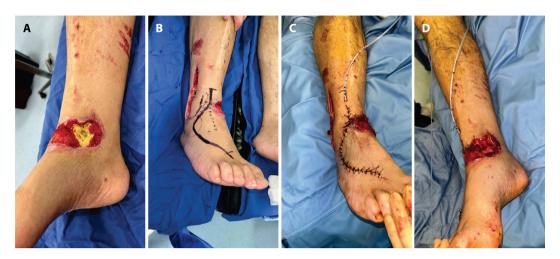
Intraoperative view. A. Bone exposure of the medial malleolus after two surgical debridements and NPWT. B. Preoperative markings. The dotted line represents the lateral tarsal artery perceived by Doppler. C. Sutured donor site. A drain was placed to prevent hematoma and it was removed the next day. D. Vital flap covering the medial malleolus bone.
